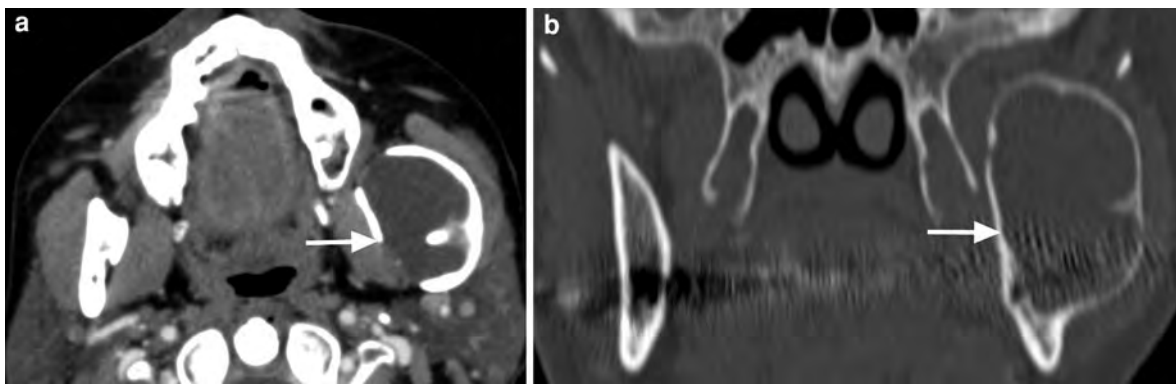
Benign intrinsic lesion of the left mandible in a 42-year-old male with numbness in the territory of the left inferior alveolar nerve. a Axial contrast-enhanced CT image shows an expansile, largely non-enhancing soft tissue mass
